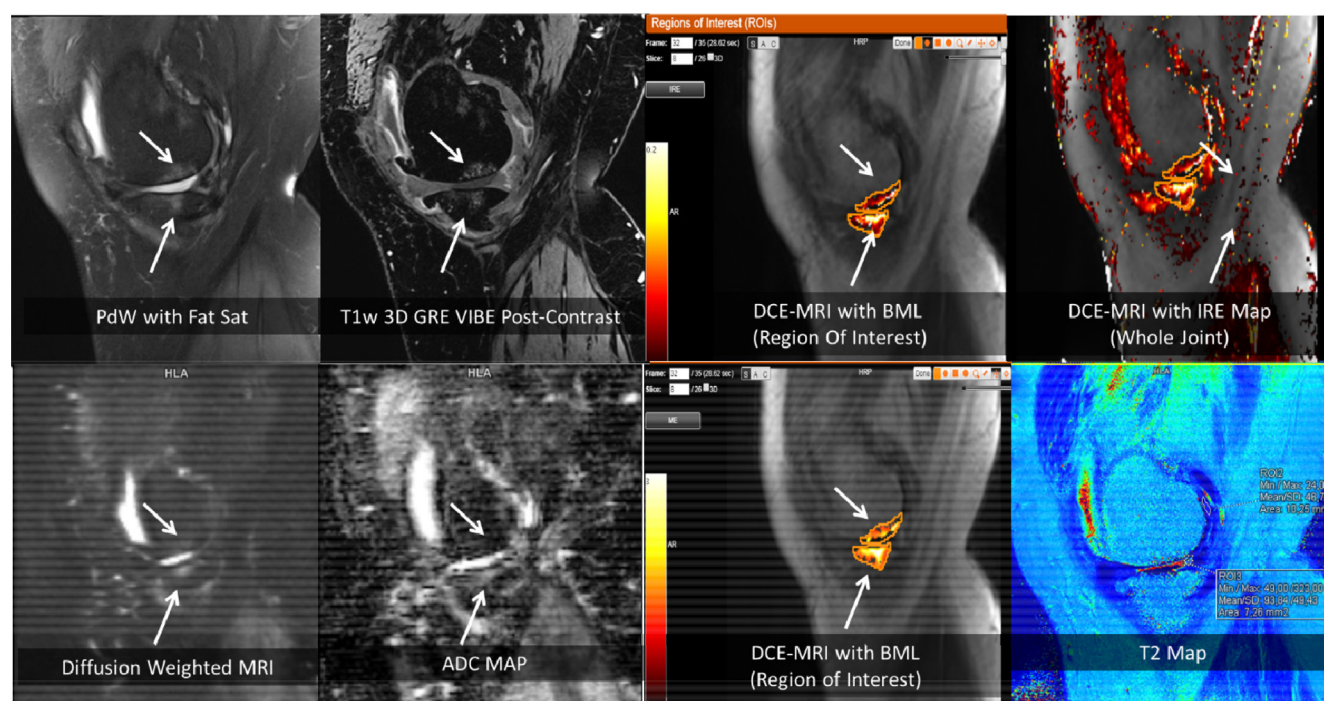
Advanced MRI sequences and corresponding quantitative maps. Arrow points indicate the bone marrow lesion (BML) at all the different sequences. Top row, from left to right: proton density weighted (PdW) sagittal image, T1 weighted gradient Echo VIBE post-contrast image, dynamic contrast enhanced (DCE) MR image and the map of initial rate of enhancement (IRE), showing areas with more inflammation in white-yellow colors and the areas with less inflammation in red colors. Bottom row, from left to right: diffusion weighted MRI, corresponding apparent diffusion coefficient (ADC) map allowing quantification of cellular density and water diffusion, DCE-MRI with the map of maximum enhancement showing areas with much perfusion in white-yellow colors and areas of less perfusion in red colors, and lastly, the T2 map showing cartilage composition. Note that the BML seen on the static and DCE-MRI sequences is not depicted on the diffusion map. On the other hand, the increased signals in the tibial plateau on the diffusion weighted sequence and the ADC maps reflect increased water diffusion, corresponding to a higher degree of perfusion (yellow colors) on the DCE-MRI sequences which might indicate a specific BML phenotype. This warrants more research. Also note that the T2 image shows high T2 values around 90 ms in the cartilage adjacent to areas of denuded cartilage (red colors), while the ROI in the posterior part of the femoral condyle has near-normal values around 46 ms.
